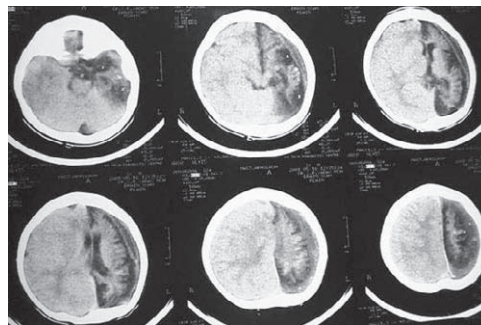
Follow up axial CT shows interval development of left hemispheric atrophy and chronic left sided subdural collection.
